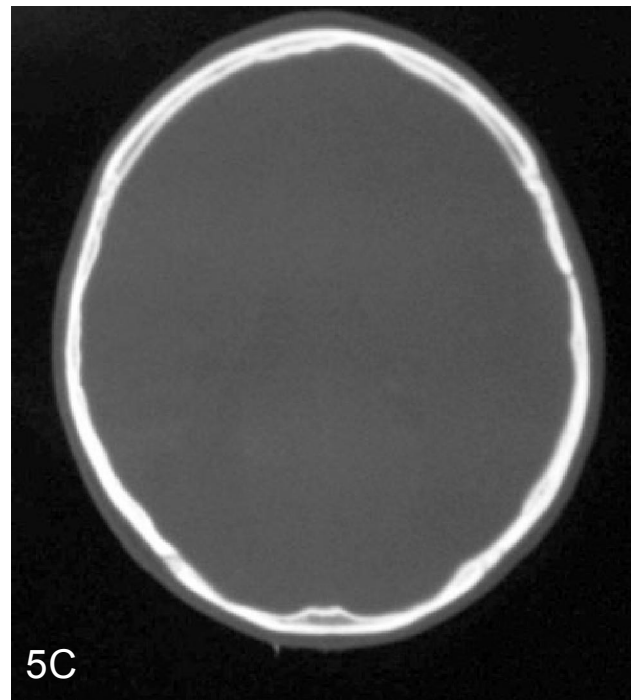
(a) Axial CT brain image of a trauma patient showing left parietal extradural hematoma and adjacent small insular contusion. (b) Small scalp hematoma also appreciated on enlarged image (c) Fracture of overlying bone visualized on bone window.
